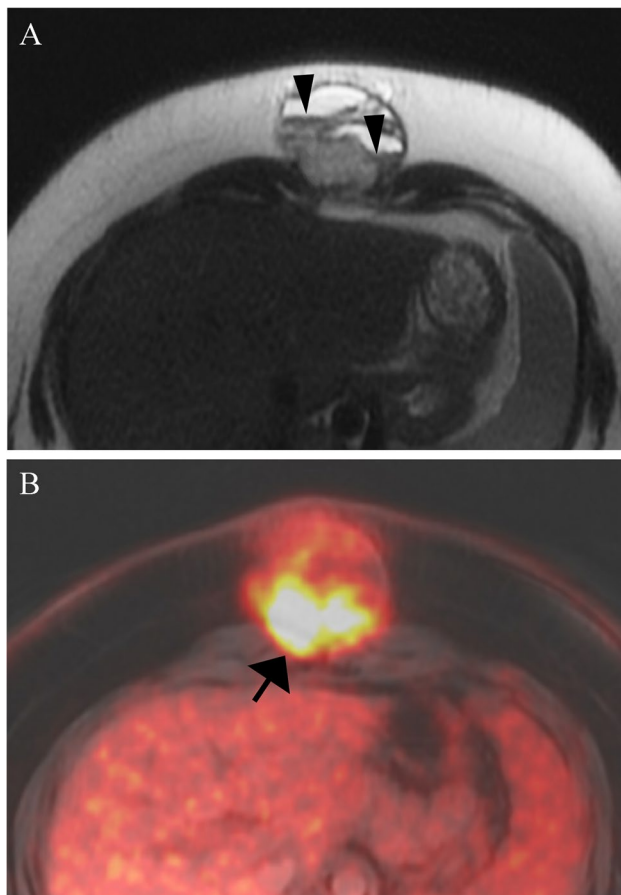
A 21-year-old woman with undifferentiated small round cell sarcoma with *CIC-DUX4* gene fusion. (A) In the axial T2 image, a few fluid levels (arrowheads) are evident in the mass. (B) Axial-fused PET MRI image shows high metabolic activity (arrow) in the tumor. The tumor showed contrast enhancement in the area with high metabolic activity on MRI (not shown)
